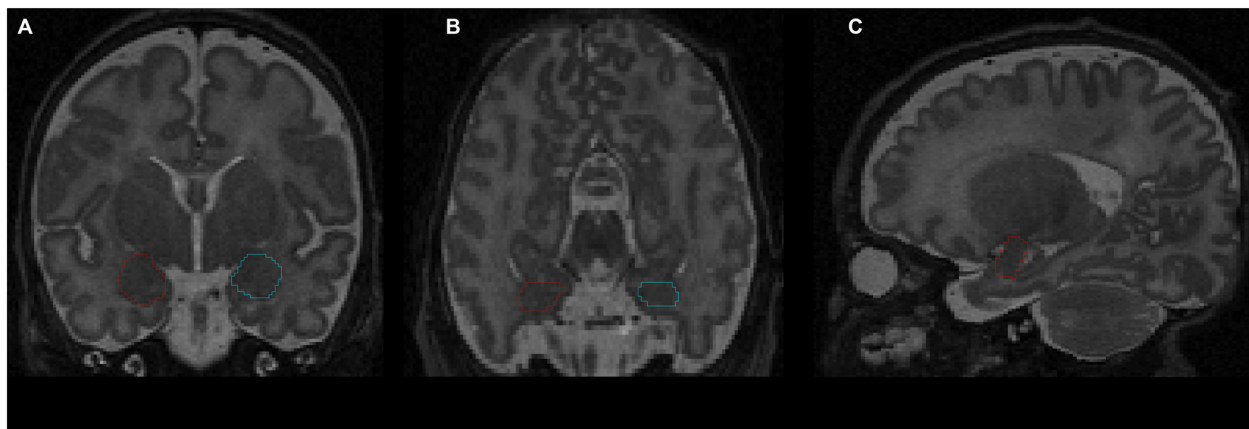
Delineation of amygdala on T2-weighted magnetic resonance imaging (MRI) using the Amira software: (A) coronal view; (B) axial view; (C) sagittal view. Red contour—right amygdala, blue contour—left amygdala.
